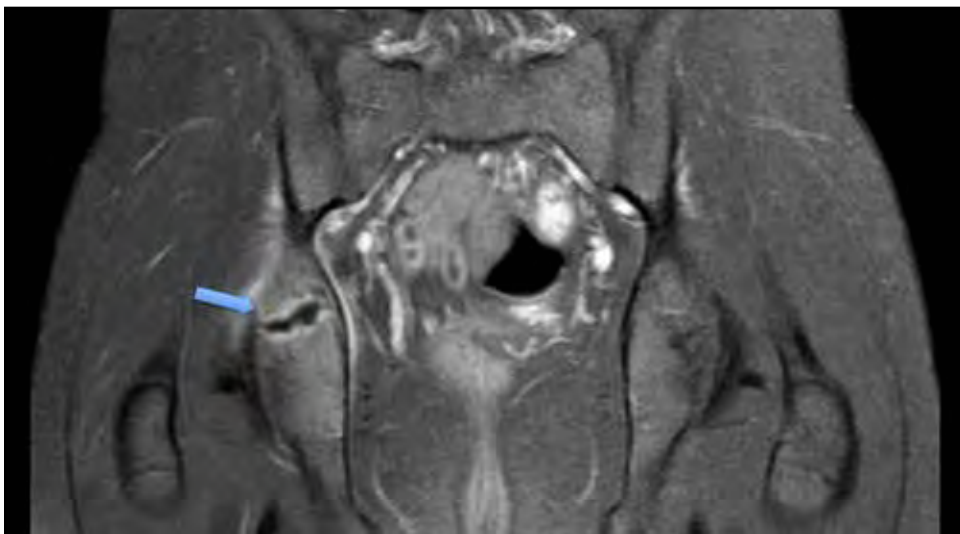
MRI IMAGE. ARROW INDICATING AREA OF NECROSIS IN TRIRADIATE CARTILAGE.
